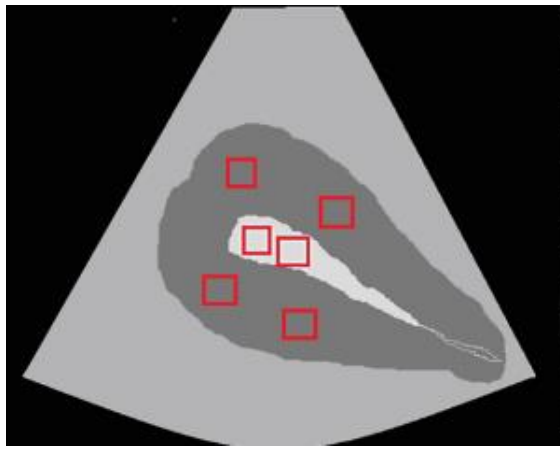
Soliman et al.'s [222] ultrasound elastography imaging sites in the midsagittal endometrium and myometrium. Reproduced from [222] © 2015 with permission from IOS Press .
